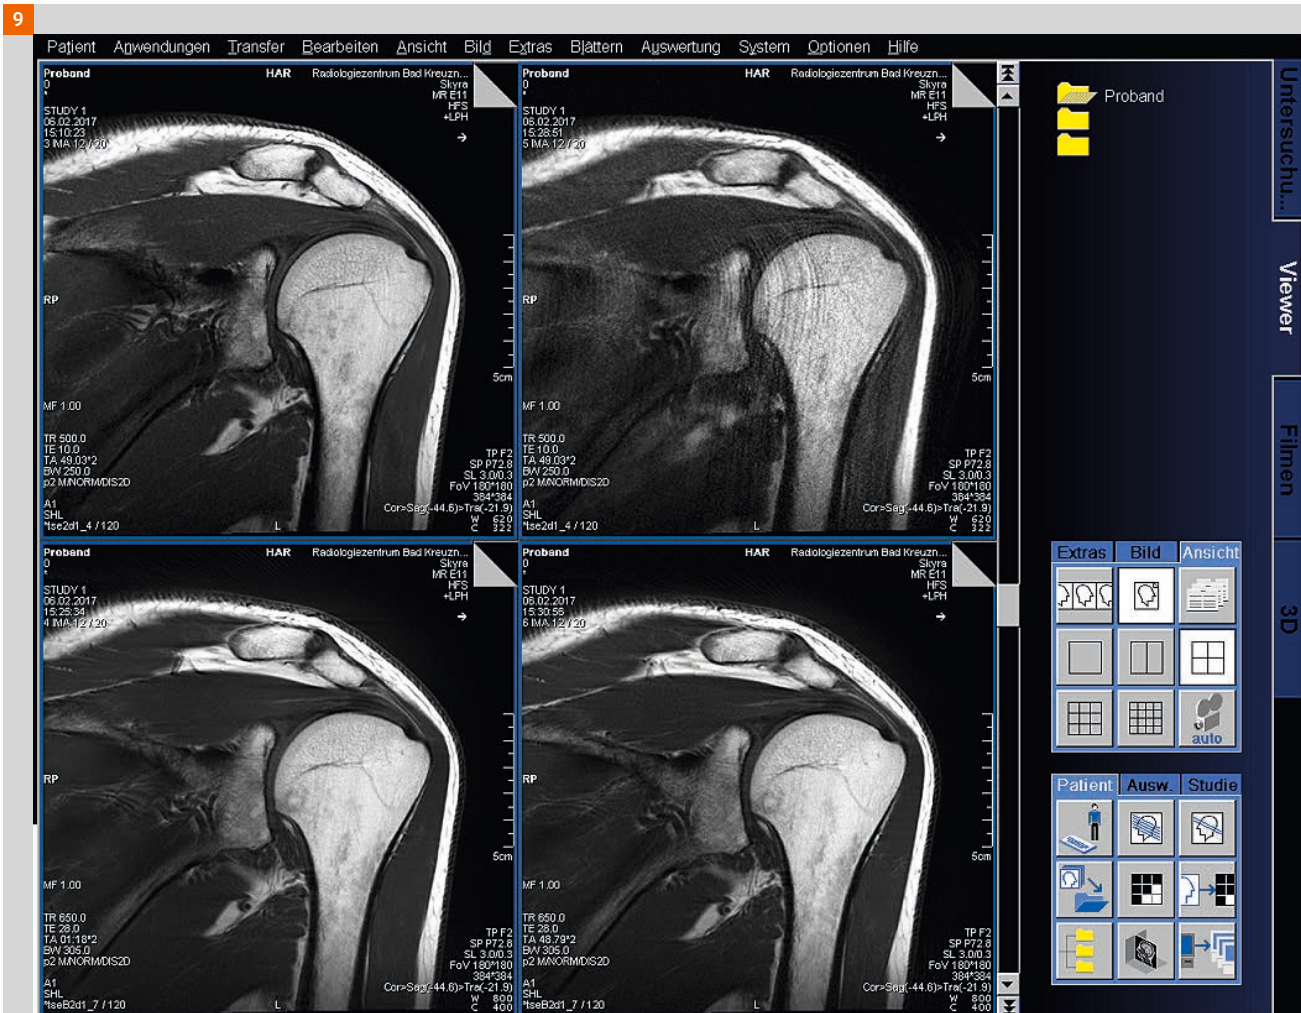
The upper left image shows a coronal T1 TSE with good image quality and a scan time of 1.40 mins. The upper right image shows the same measurement with artifacts caused by patient movement. The lower left image shows the 'true' T1-weighted BLADE with an equal image quality and contrast as the TSE. Possible artifacts, caused by patient movement, are suppressed.
